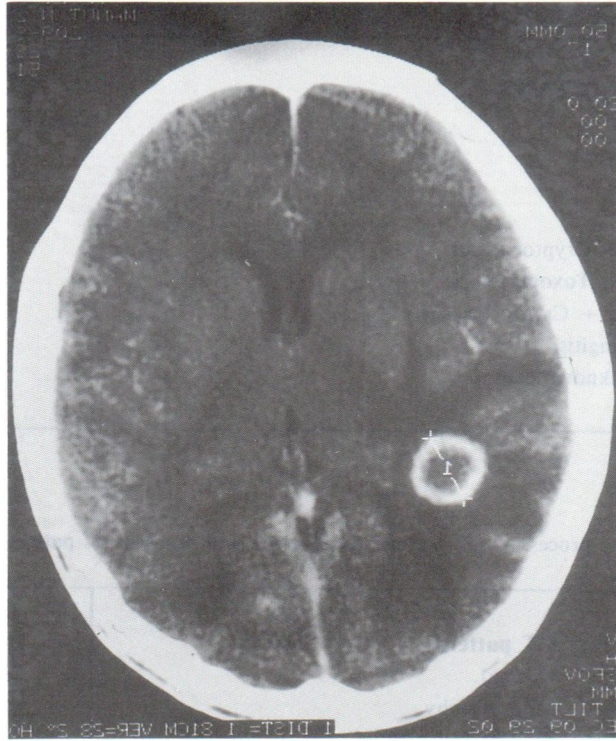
Enhanced CT scan showed a ring enhanced lesion with surrounding edema in toxoplasmosis
